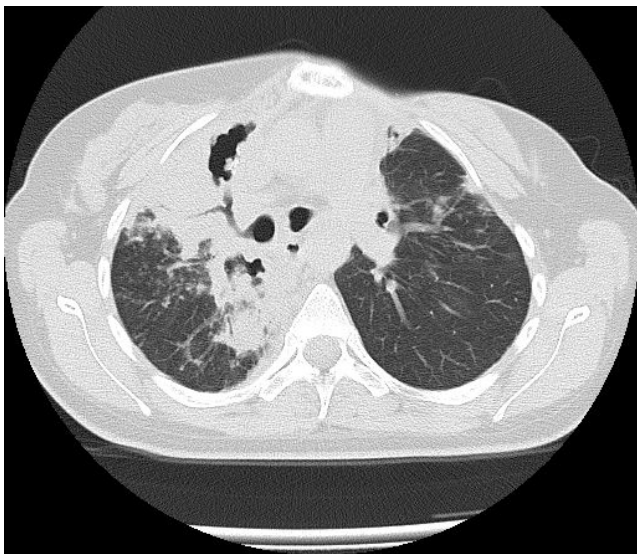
Computed tomography (CT) scans showed extensive peribronchial consolidation with bronchiectasis involving the subsegmental bronchus, and multiple centrilobular nodules and clusters of nodular at right lung. Cavities of destruction are seen filling by masses.
